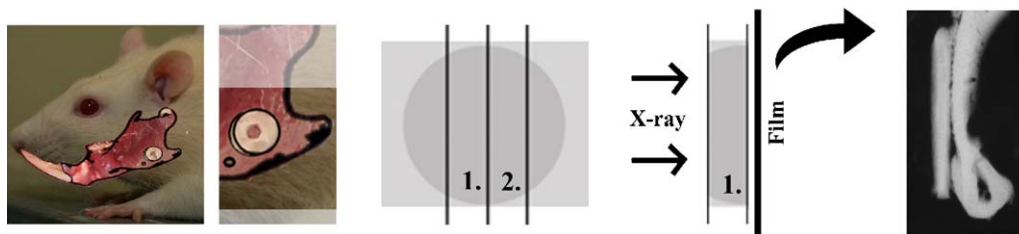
Preparation of samples and TMR. Post mortem three cuts were made in the transversal plane through the center of the graft, located at the left mandibular angle, to create two cross-sections (1 and 2). With an X-ray source transversal microradiographs were taken on film. After film development the images were magnified and digitized.
